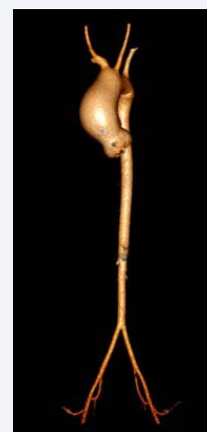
CT Aortogram showing aortic root and proximal ascending aortic aneurysm.
